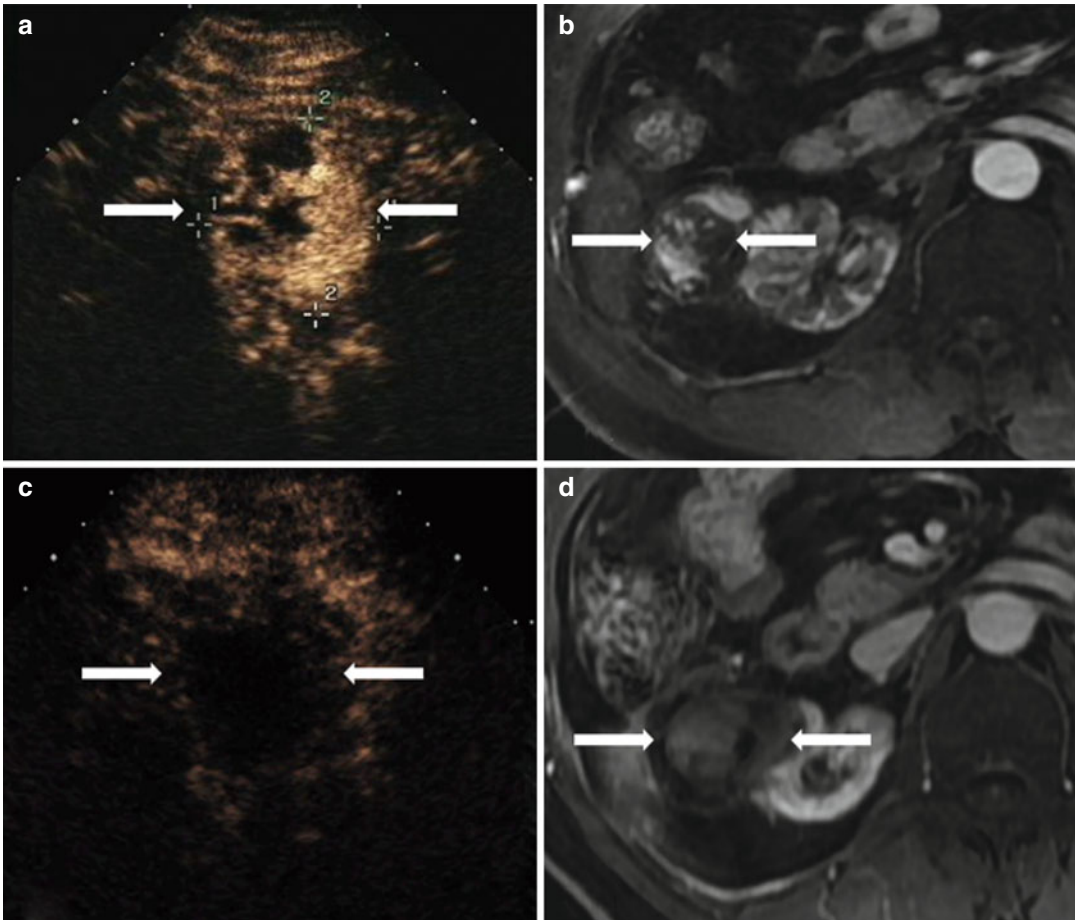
Images in a 53-year-old female with a renal clear cell carcinoma (RCC) (4.8 cm×4.5 cm) in the right kidney treated with microwave ablation (MWA). (a) Pre-ablation contrast-enhanced ultrasound (CEUS) shows a heterogeneous hyper-enhancement lesion (arrow) in cortical phase. (b) Magnetic resonance imaging (MRI) shows
